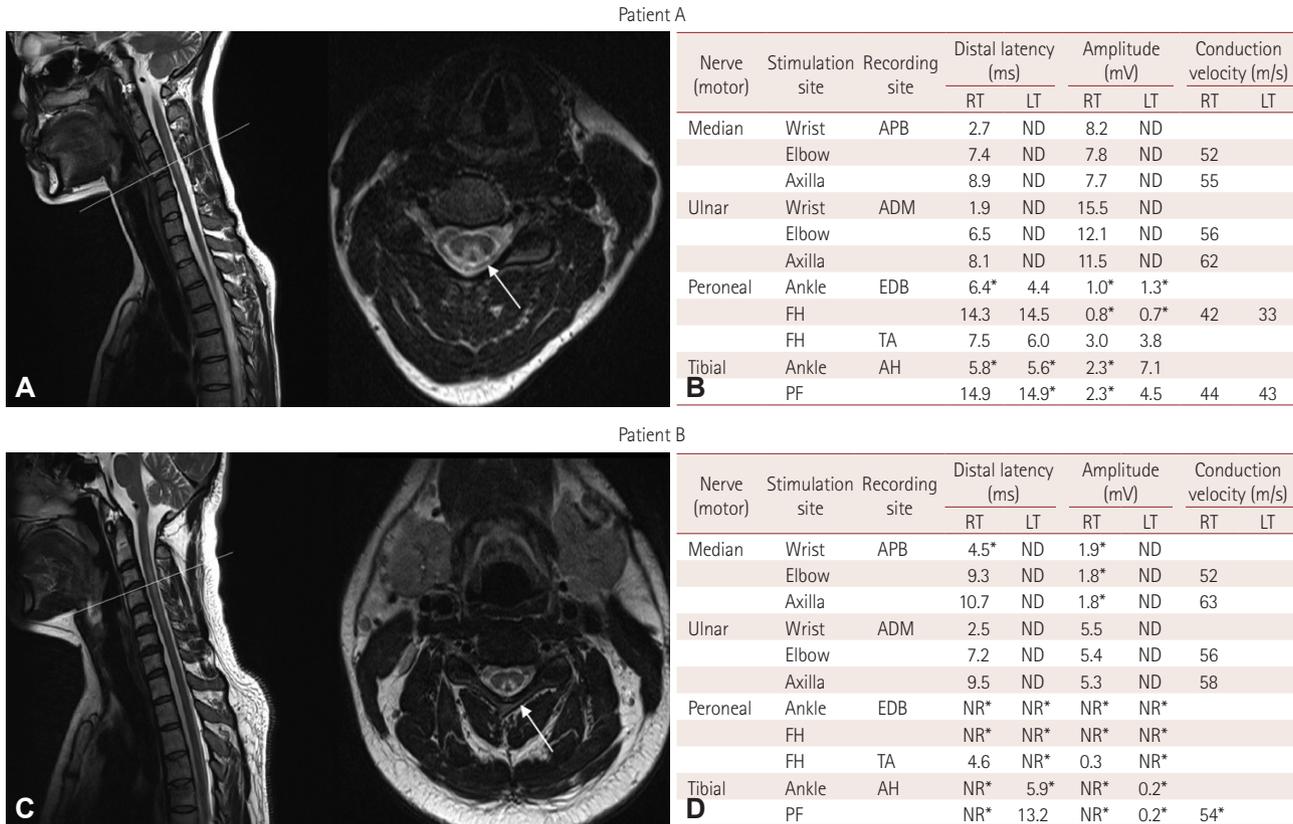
Findings of MRI and nerve conduction studies in both patients. Sagittal and axial T2-weighted images exhibited hyperintensities in the cervical cord region with an 'inverted V sign' (arrows) typical of subacute combined degeneration (A and C). Nerve conduction studies revealed axonal motor neuropathy (B and D). *Abnormal values. ADM: abductor digiti minimi muscle, AH: abductor hallucis brevis muscle, APB: abductor pollicis brevis muscle, EDB: extensor digitorum brevis muscle, FH: fibular head, LT: left, ND: not done, NR: no response, PF: popliteal fossa, RT: right, TA: tibialis anterior muscle.
